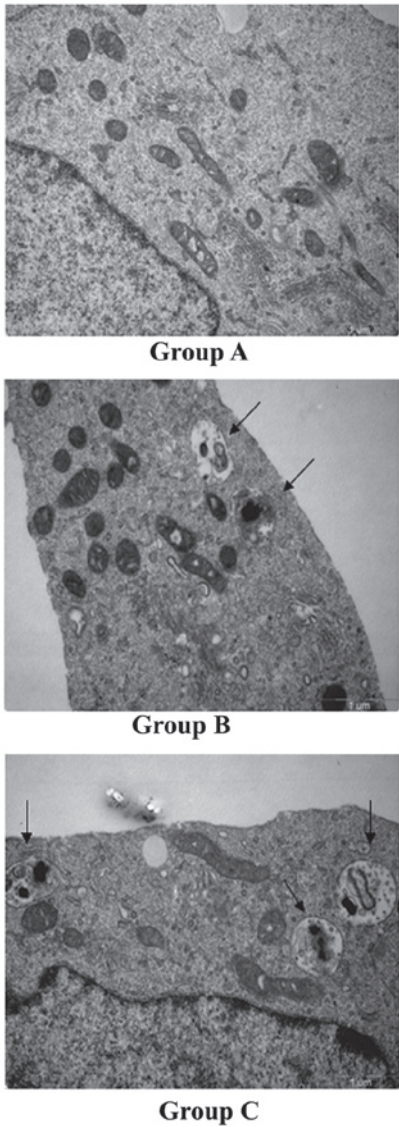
Autophagy is significantly increased in PC3 cells treated with ultrasound and microbubbles 24 h following treatment (magnification, x24,500). Group A, no treatment; Group B, cells treated with Lipofectamine® and wt-P53 plasmid; Group C: cells treated with Lipofectamine, wt-P53 plasmid and ultrasound combined with microbubbles. Arrows indicate autophagosomes. P53, tumor protein P53; wt-P53, wild-type P53.
